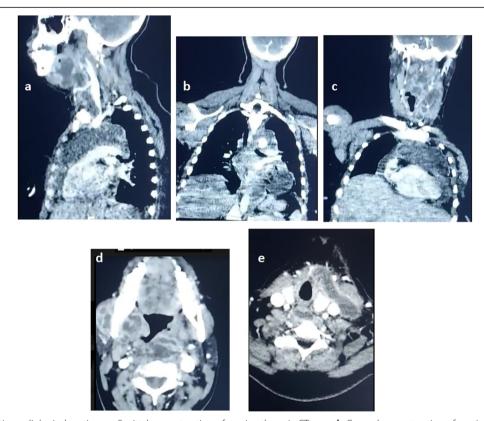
Preoperative radiological sections. a Sagittal reconstruction of cervico-thoracic CT scan. b Coronal reconstruction of cervico-thoracic CT scan residual pleural effusion. c Coronal reconstruction of cervico-thoracic CT scan showing pericardial effusion, and retro-pharyngeal and parapharyngeal collections. c Axial sections of cervico-thoracic CT scan showing sub-mandibular collections bilaterally. d Axial sections of cervico-thoracic CT scan showing retro-pharyngeal collections, communicating with anterior collection
